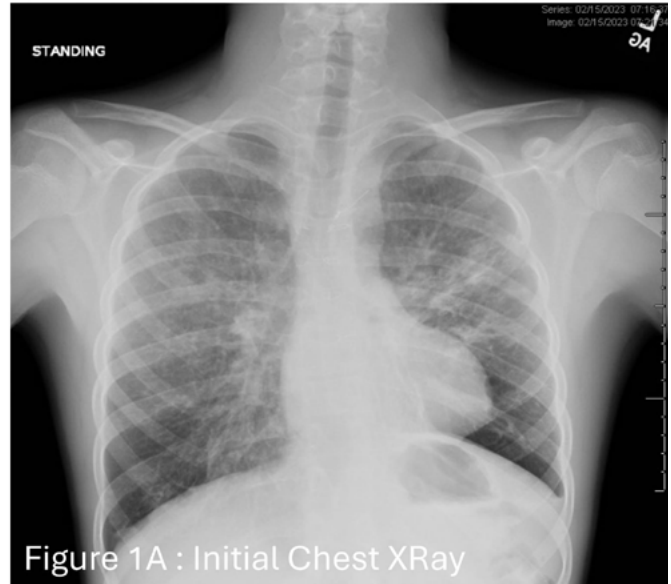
Initial Chest XRay
